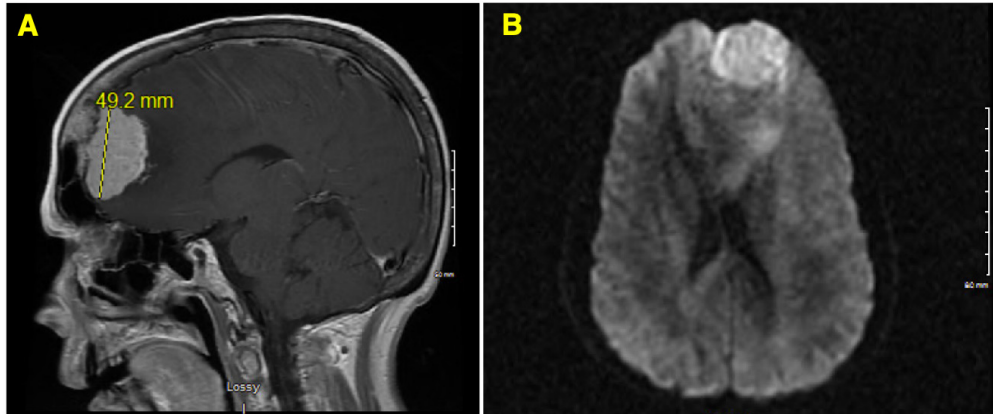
5 cm meningioma found in brain MRI. A. Sagittal view. B. Axial view.
